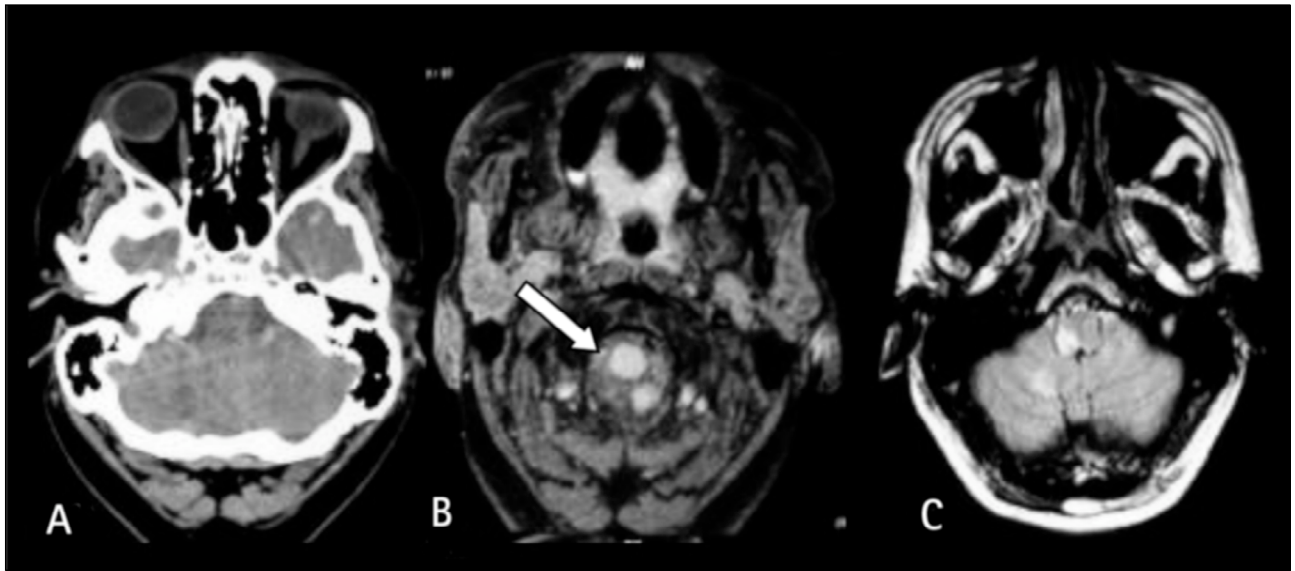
A) CT scanning: right hypodense cerebellar area. B-C) MRI: right medullar and cerebellar hyperintense signals on FLAIR. On T_2 -weighed image the lumen of the right vertebral artery is almost occluded by an intramural hematoma (white arrow).
